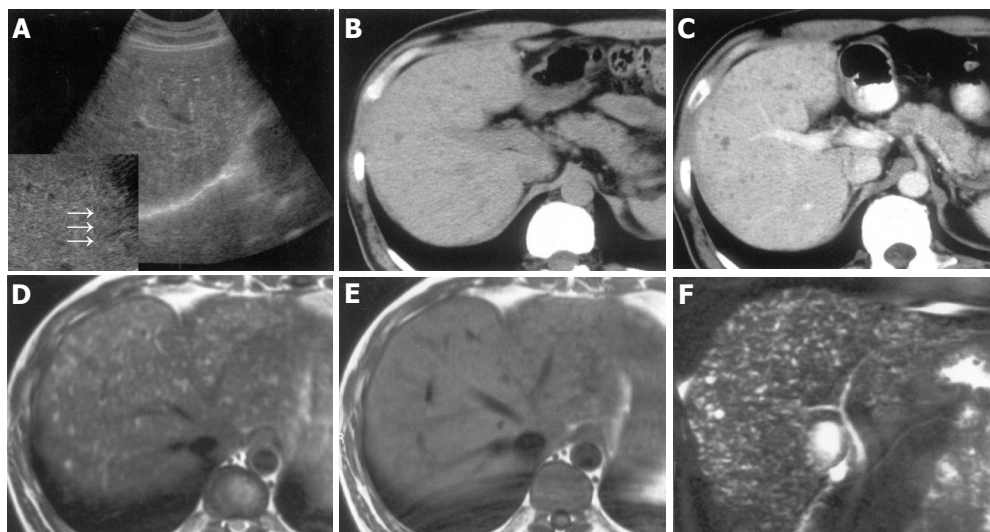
A 44-year-old man with VMCs. A: B-mode US scan with routine depth showed a vague image of multiple small hyper- and hypoechoic lesions. When magnified by using zoom function, the tiny hypoechoic lesion and the comet-tail echo were clearly seen (arrows); B,C: Multiple tiny hypodense lesions were displayed more conspicuously on enhanced CT (C) than on plain CT (B), and no enhancements were found in the lesions (C); D,E: the lesions.
